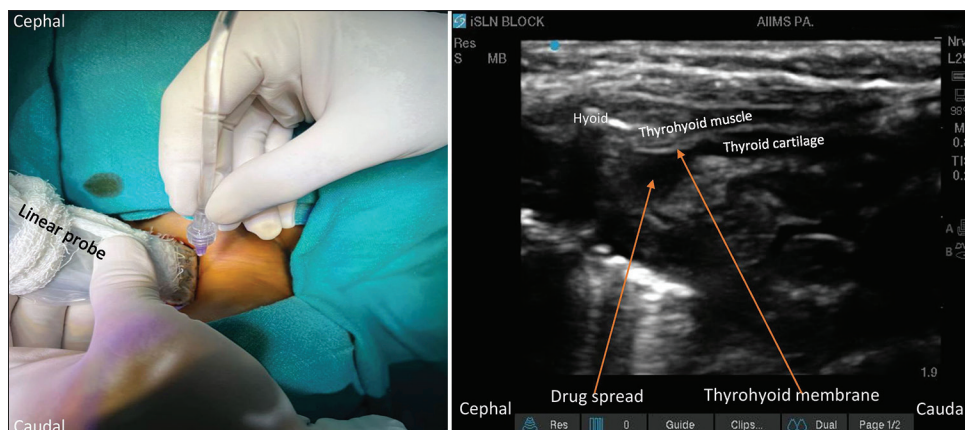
Ultrasound-guided internal laryngeal nerve block using out-plane technique
